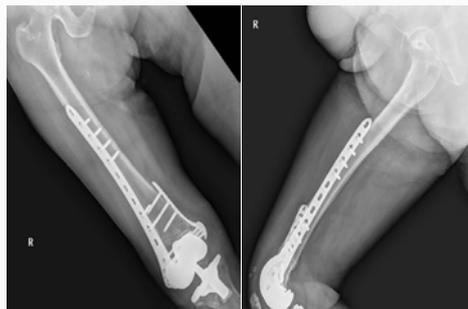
At postoperative 9<sup>th</sup> day, radiograph showed the reduction loss of fracture and fixation failure.
